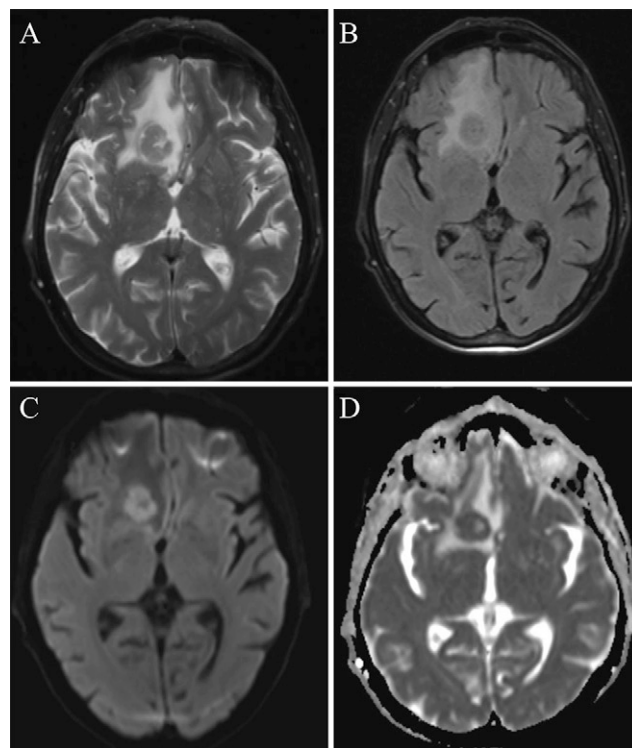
Axial fat-suppressed T2-weighted (A) and fluid-attenuated inversion recovery (FLAIR)-weighted (B) MRI sequences show a T2/FLAIR isointense inferior parasagittal right frontal lobe mass with surrounding T2/FLAIR hyperintense edema and regional sulcal effacement. Axial DWI (C) and the associated ADC map (D) depict restricted diffusion within the mass, suggesting high cellularity.
